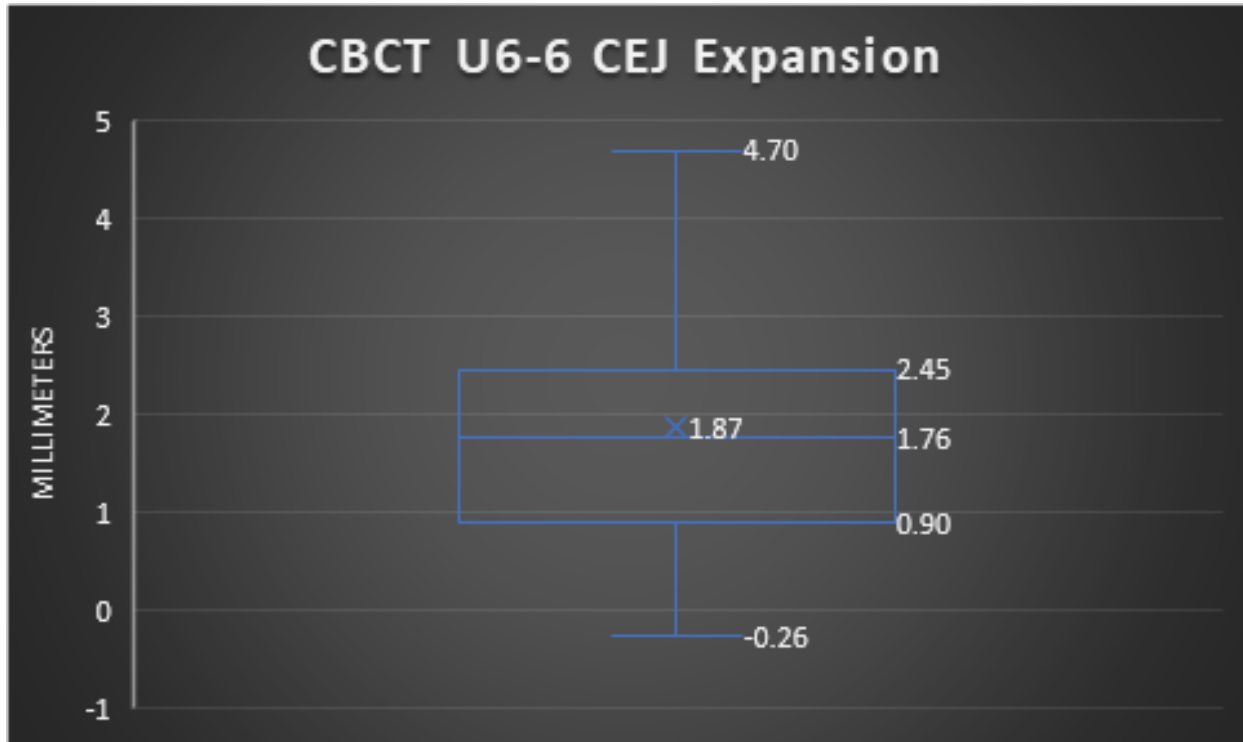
(Maxillary Molar Cementoenamel Junction Expansion shown by CBCT)
